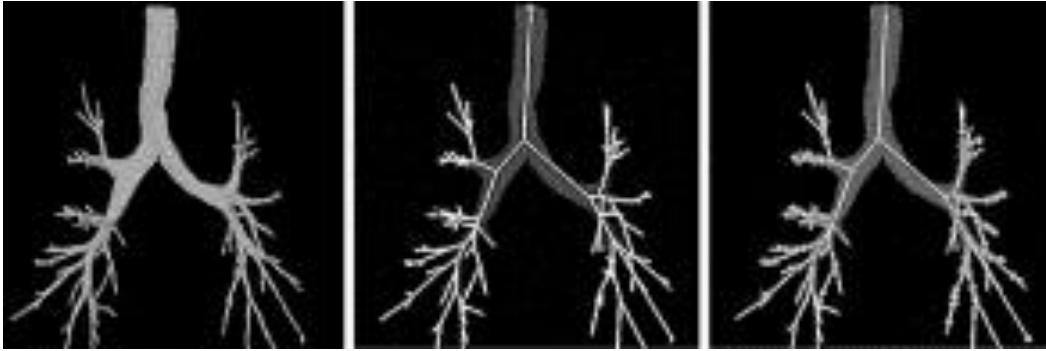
From left to right: Airway tree, center lines, and branch points which are extracted from the pulmonary CT image ([B. Li et al., 2003](#)).
